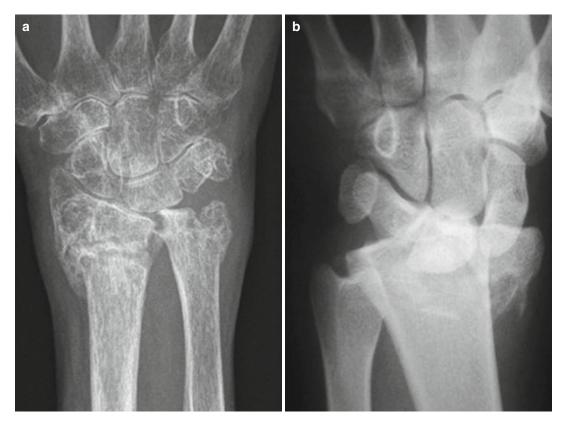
(a) X-ray of an undisplaced fracture sustained by low-energy trauma in an elderly woman with rheumatoid arthritis as a significant co-morbidity. (b) X-ray of a fracture sustained by high-energy trauma
